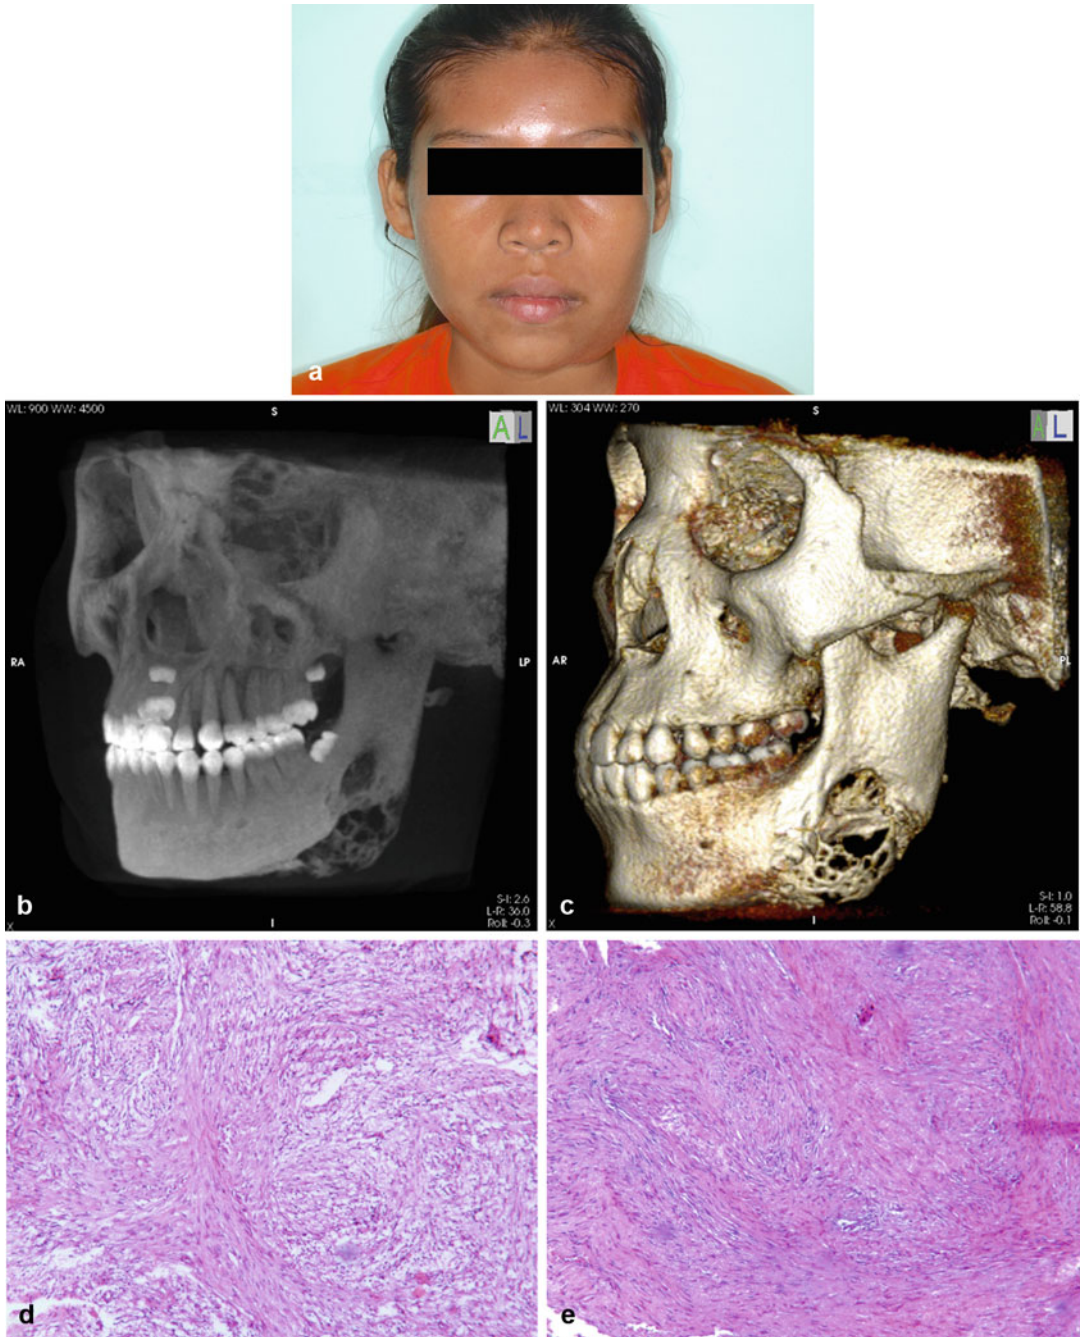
Myofibroma. Rapid growing solitary lesion involving the left mandible (a). Lytic expansile pattern of growth in the posterior mandible noted on CT
